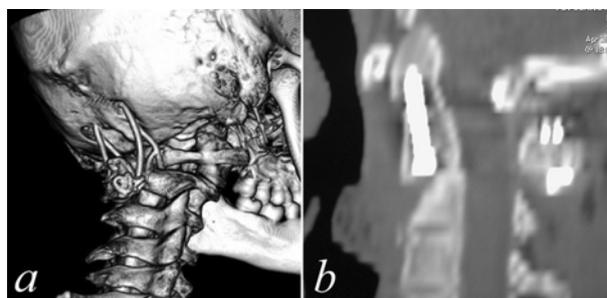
Type III dens fracture non-union managed with modified posterior occipitocervical fusion followed by direct odontoid screw fixation. a – CT 3-D reconstruction; b – fine-cut helical CT
